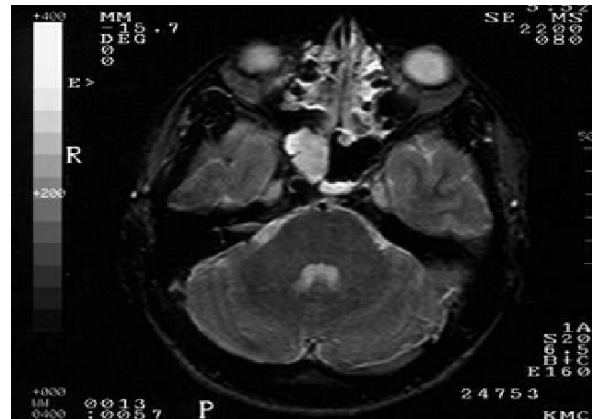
The horizontal magnetic resonance imaging of the head.
